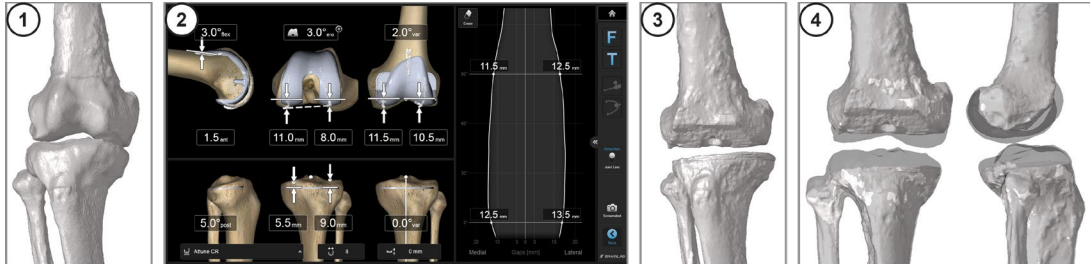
Methodology overview, 1 – preoperative CT scan, 2 – example plan on the navigation system, 3 – postoperative CT scan, 4 – registration of preoperative and postoperative CT scans for assessment
